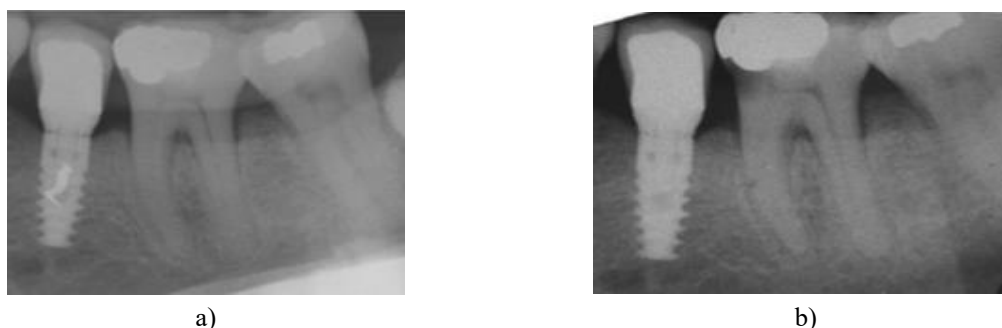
Periapical radiographs at (a) T4 (12-month review) and (b) T5 (5-year review). This patient did not attend routine control visits, and a carious lesion appeared beneath the old restoration on the mesial aspect of the neighboring tooth.
